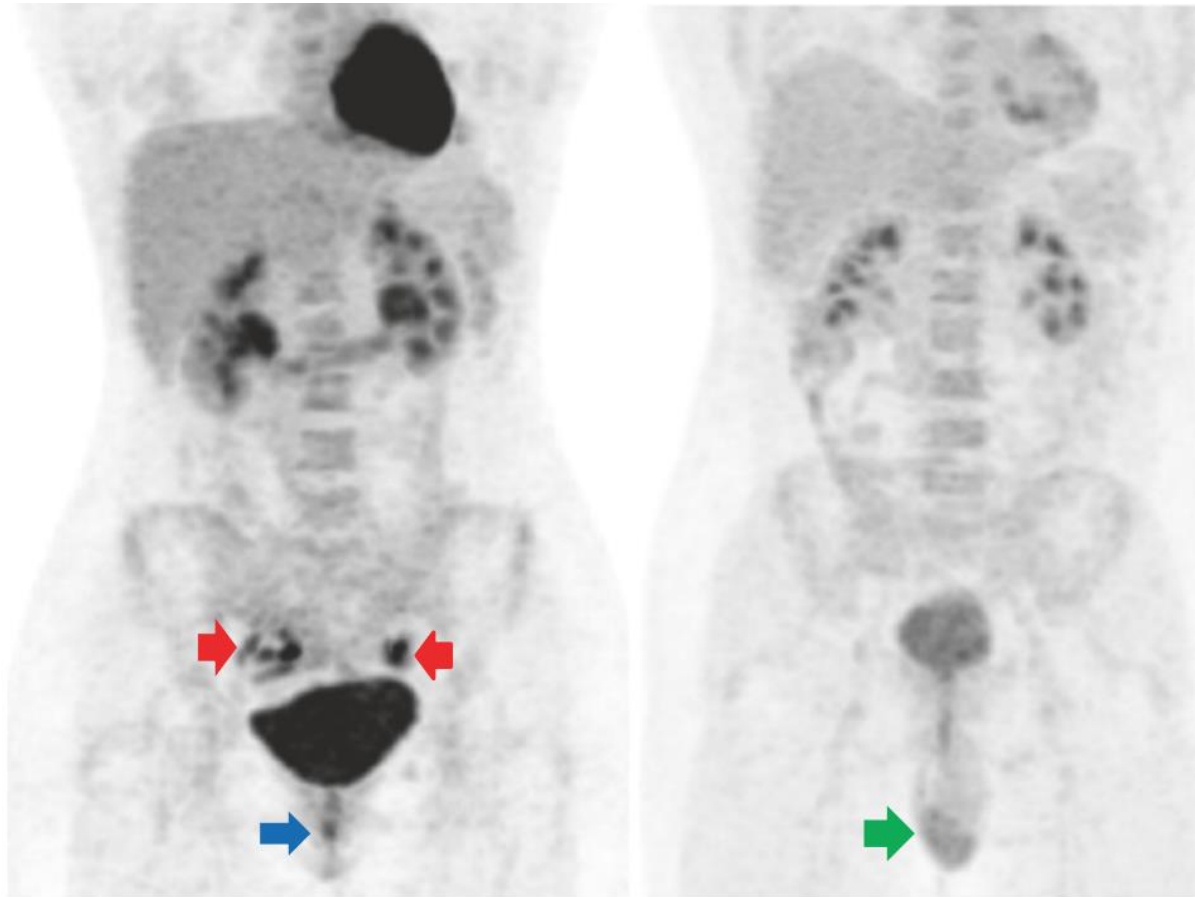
Physiological FDG uptake in the abdomen and pelvis: Usually most intense FDG activity is noted in the pelvicalyceal system, ureters, and urinary bladder. Physiological but less intense FDG uptake is noted in the liver, spleen, bone marrow, and renal cortices. Physiological (variable) FDG uptake may be seen in the uterus and ovaries (red arrows) depending on the phase of menstrual cycle. Physiological (low to moderate grade) FDG uptake may be seen in the testes (green arrow). Focal FDG uptake at the anus (blue arrow) is due to sphincter activation or local inflammation.
